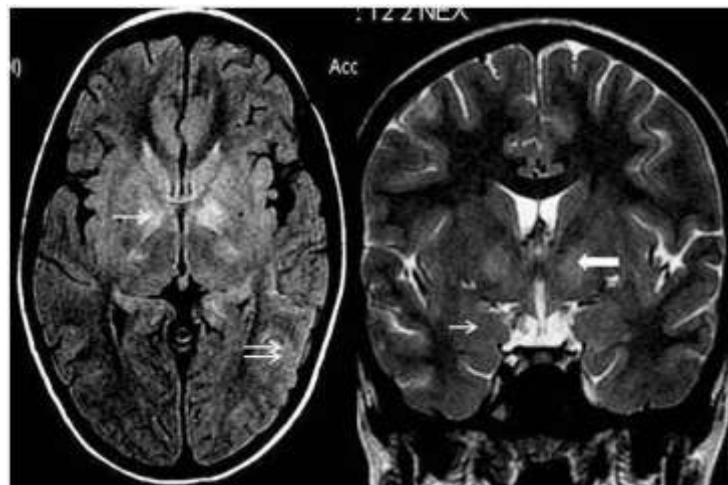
Axial T2 FLAIR MRI showing hyperintense signals in bilateral globus pallidus (single arrow) and in left parieto-occipital region (double arrows). Figure 1B: Coronal T2 weighted image demonstrating the symmetrical altered signal in bilateral globus pallidus (thick arrow) and bilateral medial temporal lobe (thin arrow)
